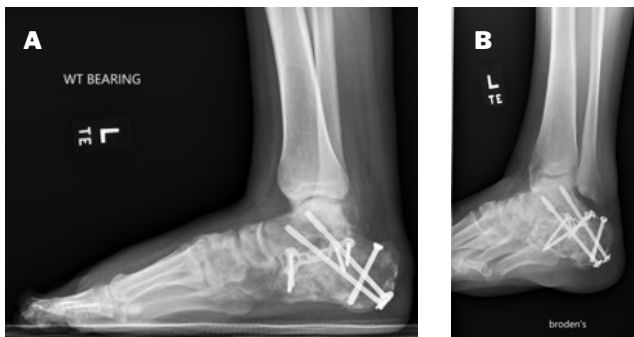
(A-B): X-rays at 3 months post op. Evidence of trabeculation across the subtalar joint and consolidation of calcaneal fracture. Note maintenance of normal talar sagittal plane alignment. A. Lateral view. B. Broden's view.
